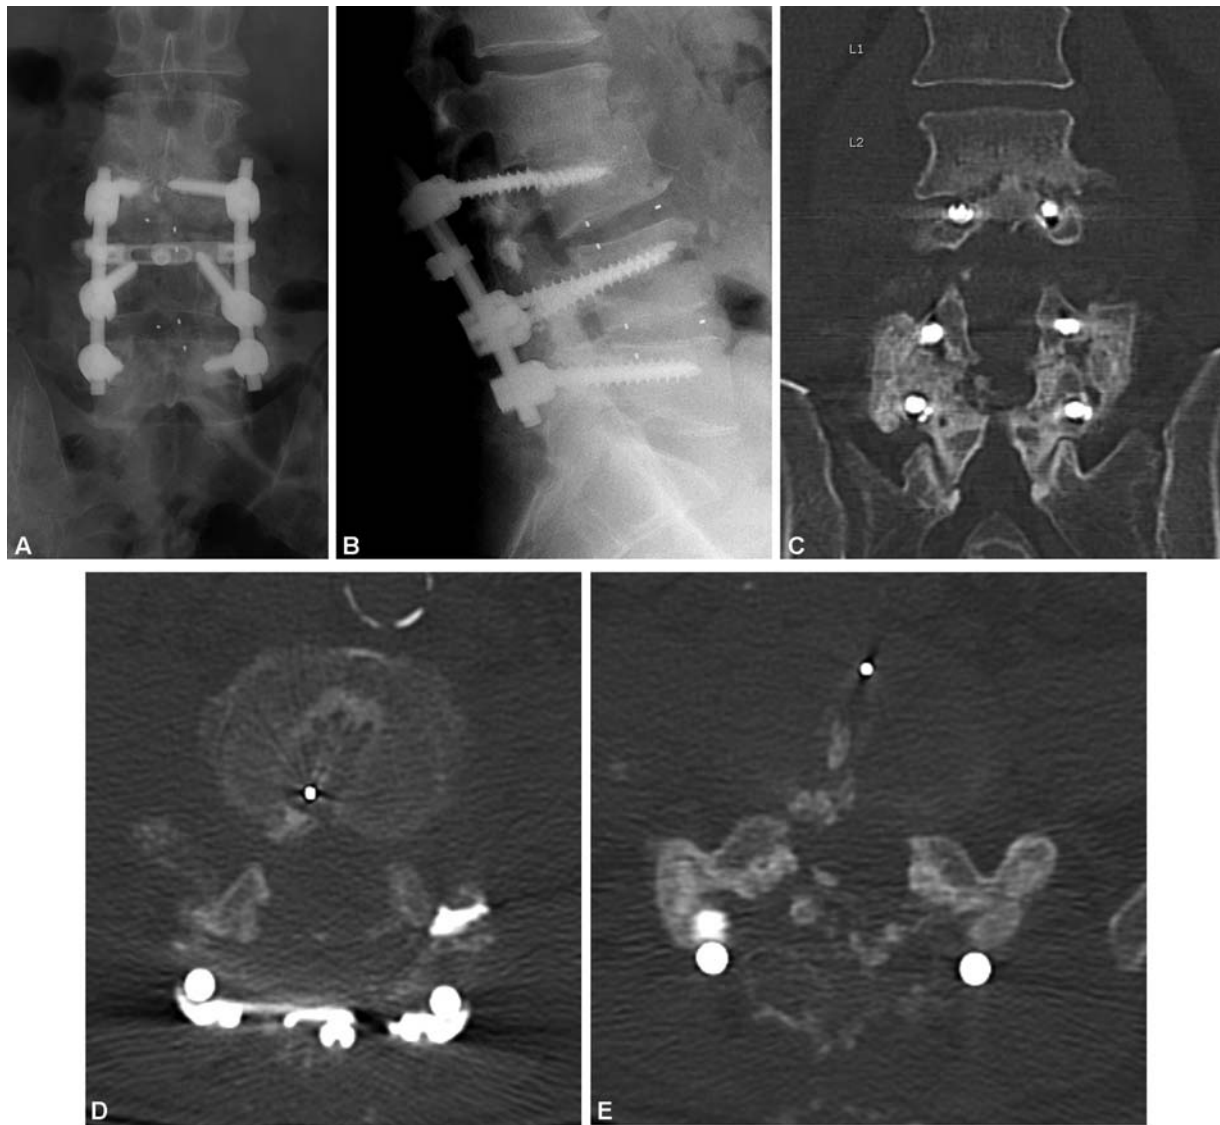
A 67-year-old man, smoker, 4 years s/p multiple posterior lumbar spinal surgeries, complicated by postoperative surgical site infection treated with multiple debridements and antibiotics. Static AP and lateral radiographs demonstrate posterior instrumentation and interbody devices spanning L3–5 and adjacent-level kyphotic collapse (A,B). Fractured L3 pedicle screw is indicative of pseudoarthrosis at L3–4, although intertransverse fusion mass is seen spanning L4–5. Fine cut axial CT scan with coronal reconstruction confirms failure of fusion at L3–4 (C,D), but solid arthrodesis at L4–5 (C,E). s/p, status-post.
